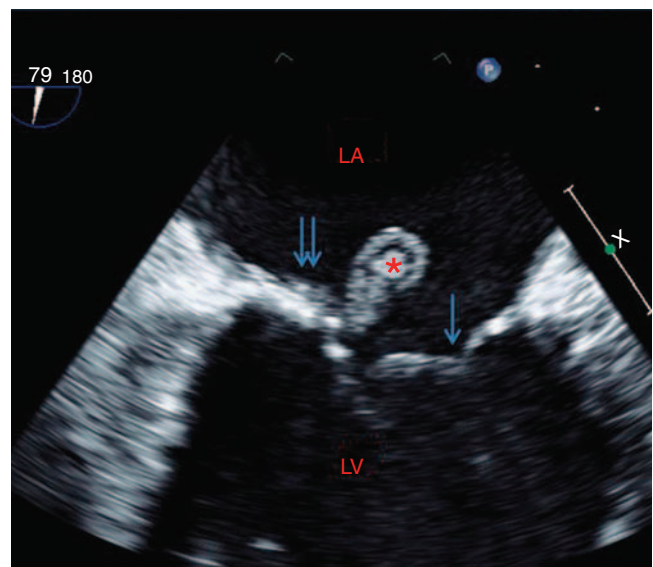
Two-dimensional transesophageal echocardiogram image of the mitral valve (MV), anterior MV leaflet (↑), and posterior MV leaflet (↑↑) with a vegetation (*) attached by a stalk to the left atrial (LA) side of the posterior MV leaflet, near its tip. LV, left ventricle.
